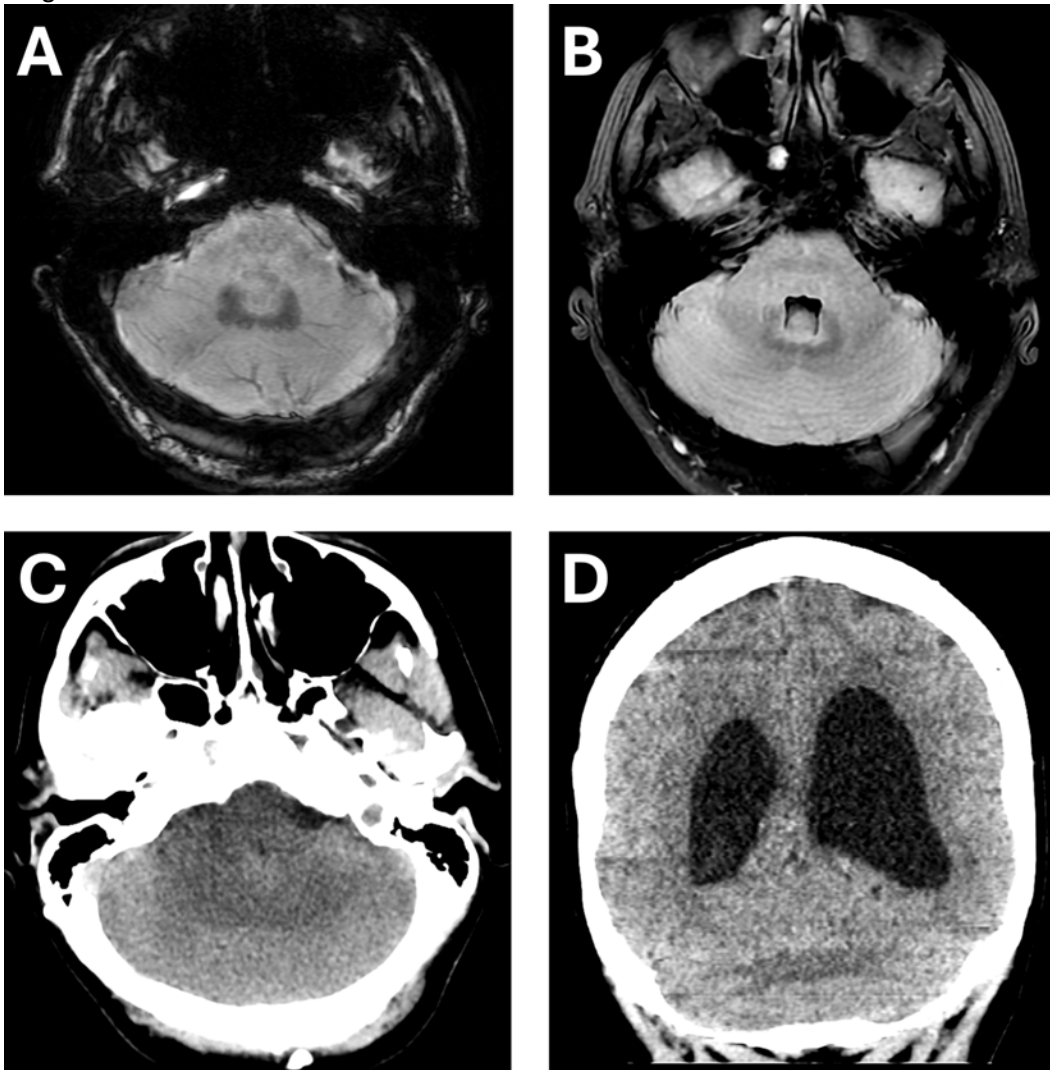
Axial susceptibility-weighted MRI reveals fusion of the dentate nuclei (A). On axial FLAIR images (B), the cerebellar vermis is absent and the cerebellar hemispheres are fused, with an abnormally shaped fourth ventricle. CT imaging in axial (C) and coronal (D) planes demonstrates midline fusion of the cerebellar hemispheres with continuous white matter across midline.
